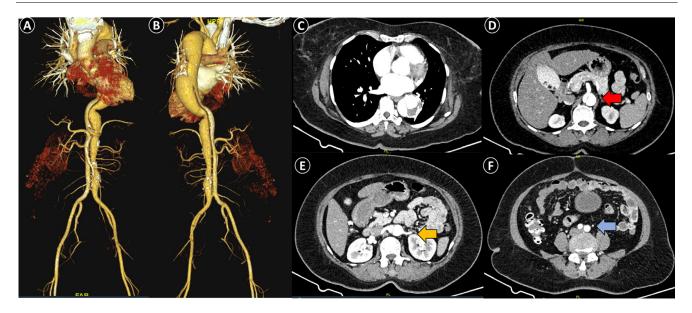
Three-dimensional reconstruction (3D) computed tomography angiography (CTA) anterior (A), and posterior (B) views revealed persistent double dorsal aorta. The axial view shows the celiac artery arises from the right lumen (red arrow) (D), the right renal artery from the right lumen, the left renal artery from the left lumen (orange arrow) (E), and each lumen terminates as right and left common iliac artery (blue arrow) (F).
